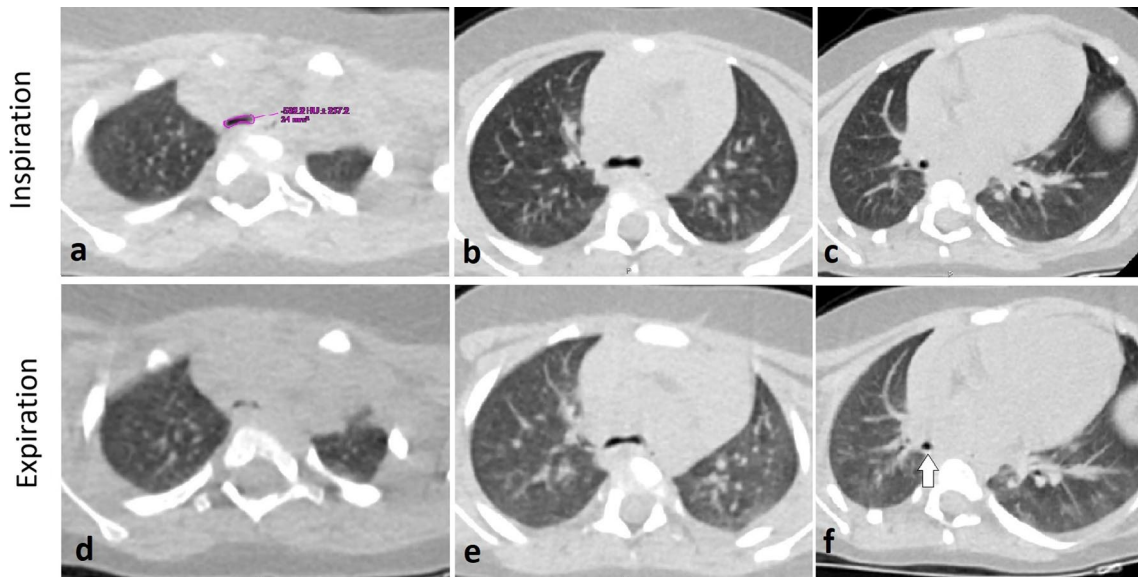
Different degrees of expiratory central airway collapse perceived by cine CT at different airway levels. Free-breathing cine CT images obtained at end-inspiratory and end-expiratory phases revealed class 3 ($\geq 70\text{--}99\%$) expiratory airway collapse at thoracic inlet level (a, d), class 2 ($\geq 50\text{--}70\%$) airway collapse at carina level (b, e) and class 1 ($< 50\%$) airway collapse at bronchus intermedius level (c, f). At bronchus intermedius level, mild airway collapse is diagnosed by flattening of its posterior wall during expiratory phase (arrow)
